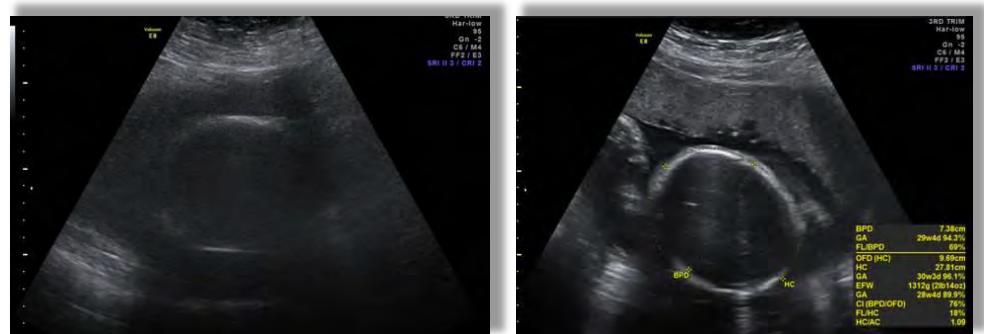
Image source: Donna Traves Sonographer, RBWH
